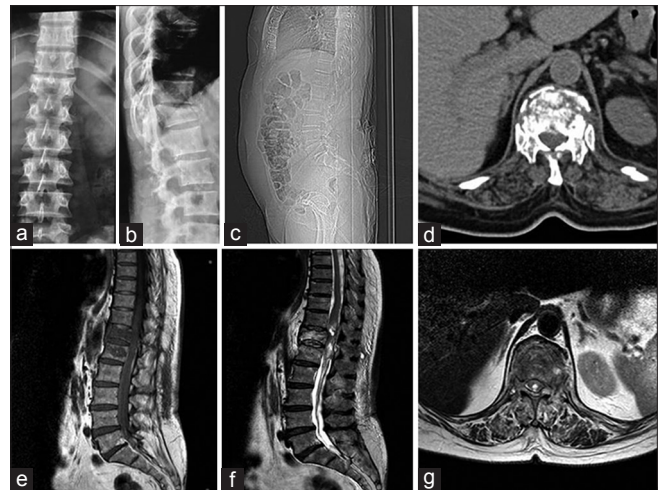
A 65-year-old female had a road side accident 28 h prior to investigations. Clinical examination showed initial AIS Grade A. Radiograph, computed tomography (CT), and magnetic resonance imaging (MRI) features at the time of initial presentation. (a and b) Plain radiograph (anteroposterior and lateral views) shows wedge collapse of the D12 vertebra. Radiological measurements showed sagittal index, Gardner's index, and regional kyphosis values of 7°, 14°, and 15° respectively. CT scan measurements showed canal dimensions, compression percentage, and Beck index values of 15.21, 6%, and 0.95, respectively. (c and d) MRI sagittal T1-weighted, (e) sagittal T2-weighted, (f) and axial T2-weighted (g) images show maximum spinal cord compression, maximum canal compromise, and lesion length values of 23%, 43%, and 86.06 mm respectively. Hemorrhage, cord swelling, soft tissue injury, body fracture, altered marrow signal, and posterior ligamentous complex injury are also present
